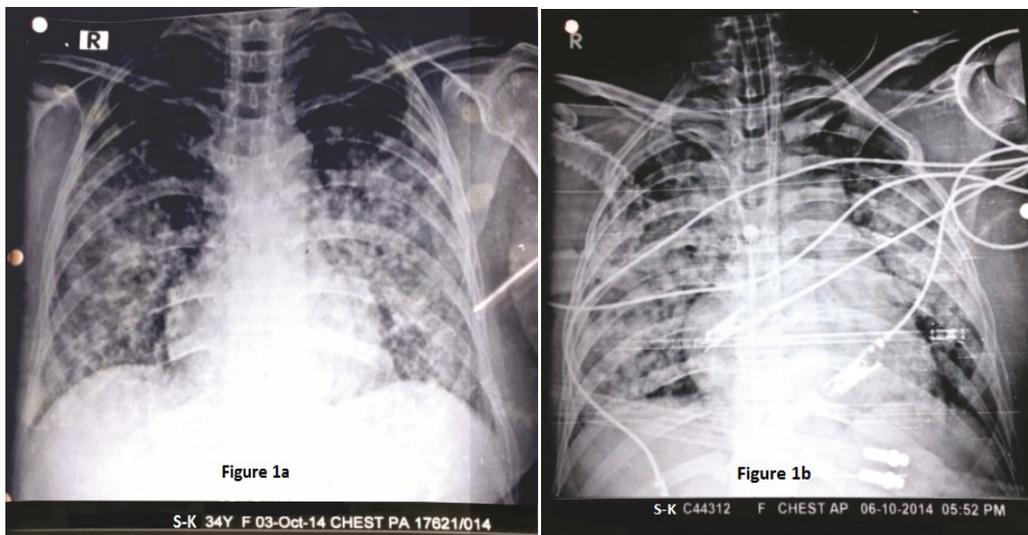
Chest radiograph showing bilateral reticulo-nodular shadowing involving the mid-zones and the lower zones.
